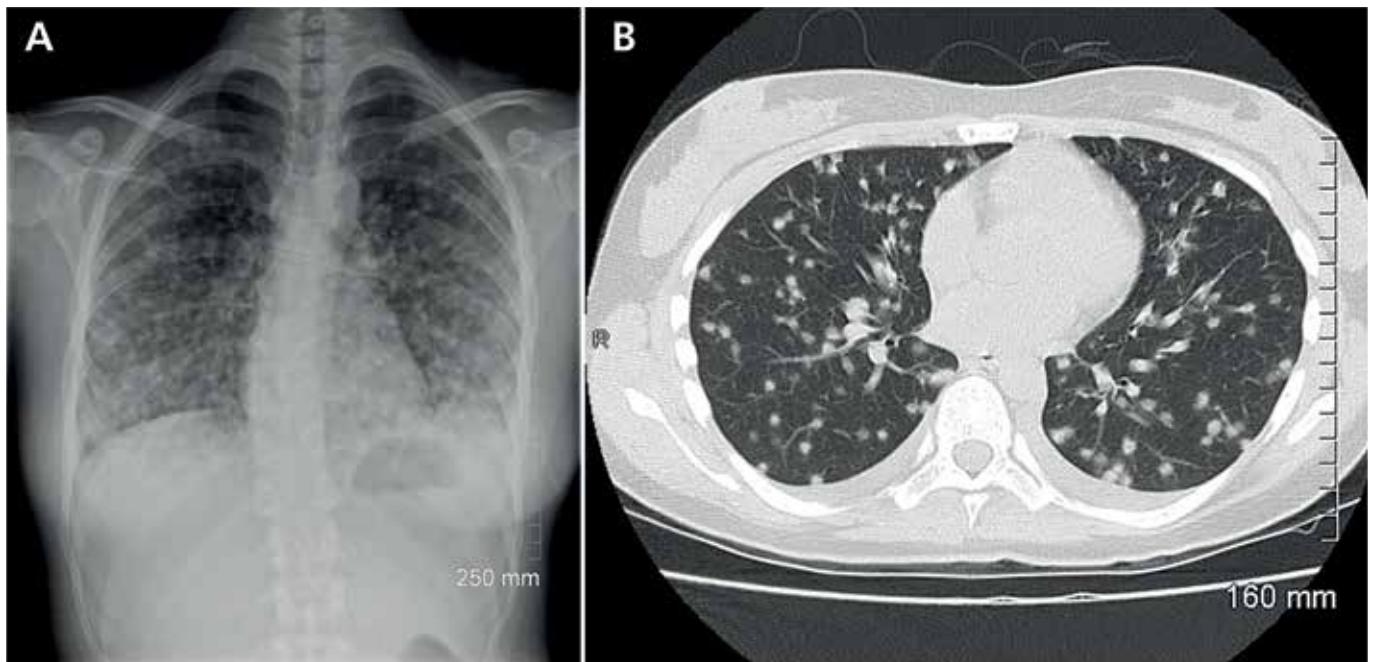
Extensive bilateral nodular lesions in the lungs caused by histoplasmosis on a chest X-ray (A) and a CT scan (B).
